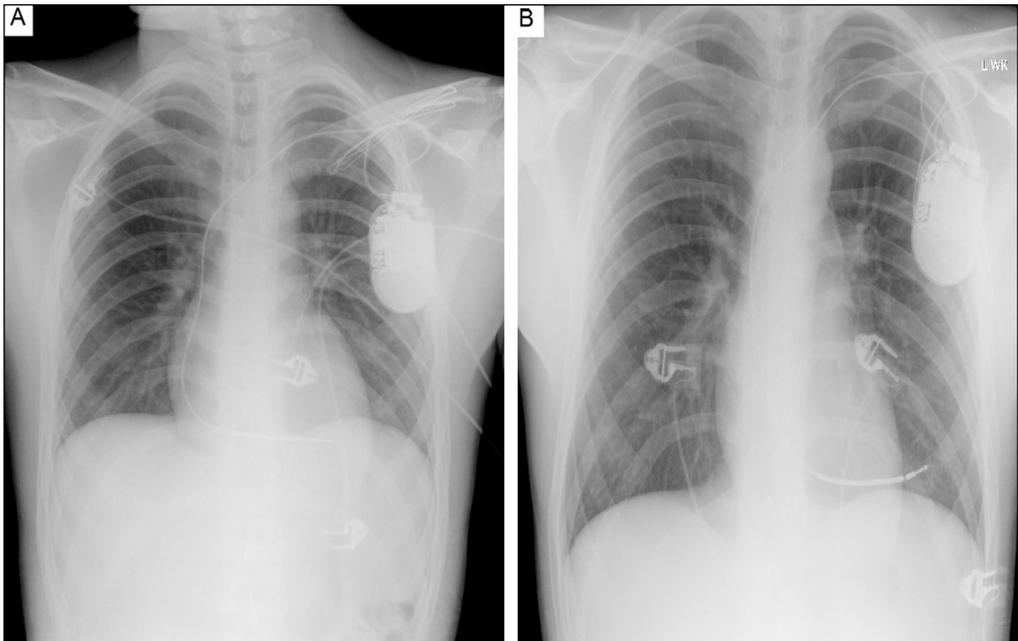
A: Chest-X-ray prior to primary discharge showing no pathologic findings B: Chest-X-ray demonstrating the extracardiac tip position of the active-fixation lead, perforating the right ventricle and the lung.
